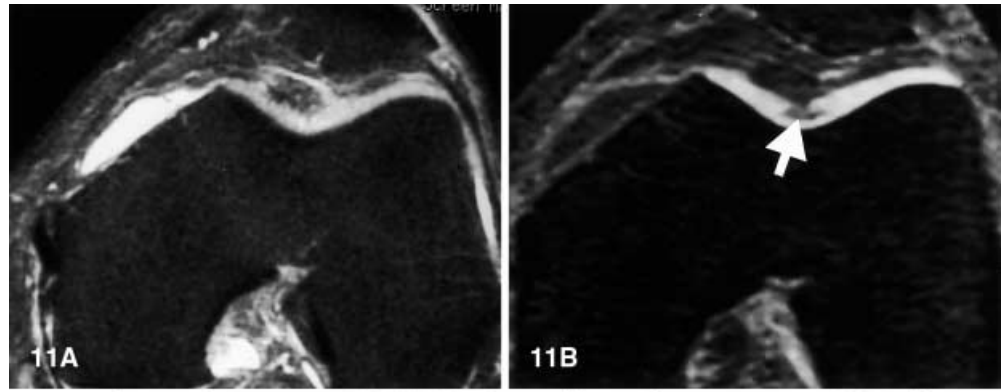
Acute chondral defect in a 14-year-old soccer player. (Adapted and reproduced, with permission, from [6].) A Sagittal T2-weighted spin-echo image (1700/80, TR ms/TE ms) shows no abnormality in the femoral trochlea. B Sagittal fat-suppressed three-dimensional spoiled gradient-echo image (60/5; flip angle, 40°) shows a large full-thickness defect (*arrowheads*). Note the abrupt margins of the defect (*open arrow*). A cartilaginous loose body was present in the suprapatellar recess (not shown)
